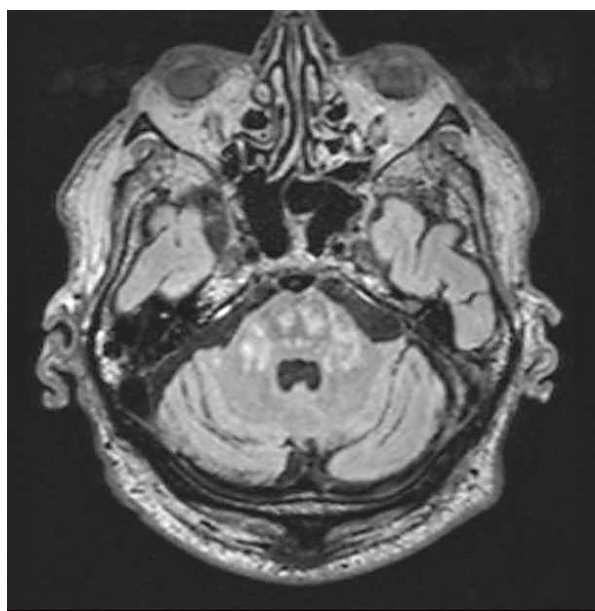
Axial FLAIR MRI shows multiple punctate and patchy regions in the pons and cerebellar peduncles.
